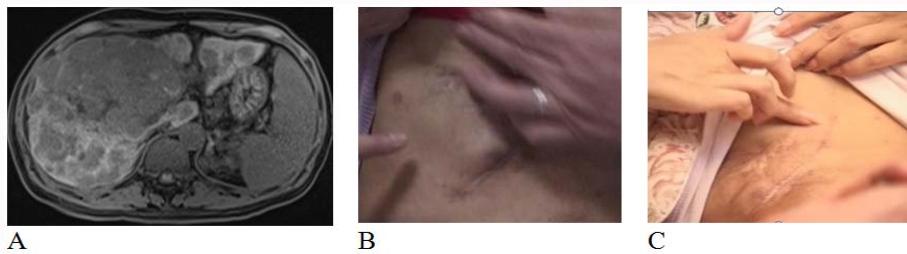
The imaging findings of case 5. A: CT shows large masses of multiple space-occupying lesions in the liver and hilar; B: multiple metastatic nodules under the abdominal wall before TTV treatment; C: subcutaneous nodules disappeared after TTV treatment.
